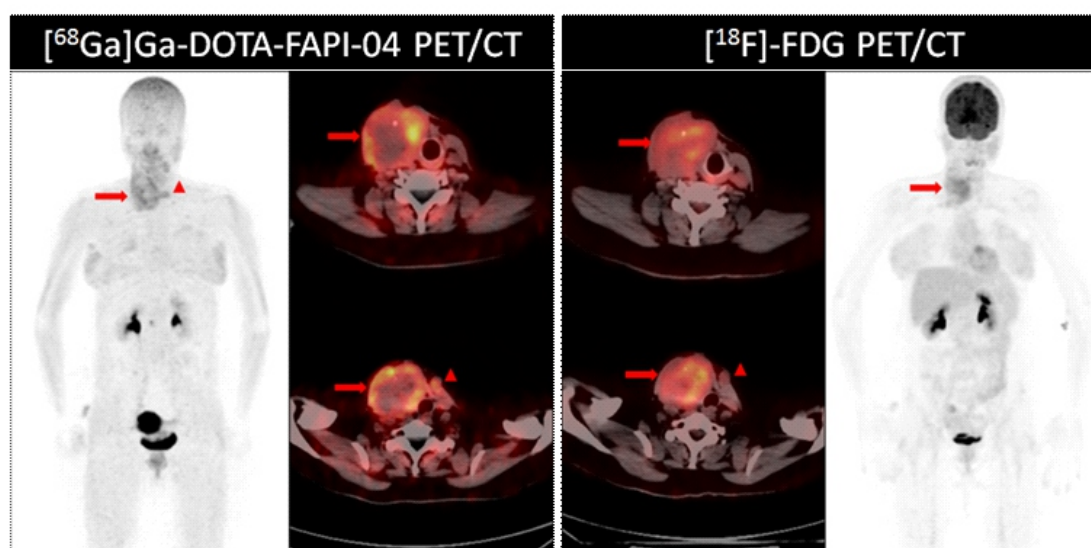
A-31-year-old woman with papillary thyroid cancer (Encapsulated follicular variant) who has had a total thyroidectomy and now has recurrent disease. Significant activity uptake was noted in conglomerated lymph nodes (arrow) on the right anterolateral side of the neck with both modalities (^{68}Ga -FAPI PET/CT SUVmax: 7.4; ^{18}F -FDG PET/CT SUVmax: 7.4). In contrast, ^{68}Ga -FAPI PET/CT imaging revealed a more distinct distribution of activity. In addition, the lymph node positioned on the left anterolateral side of the neck (arrowhead) demonstrated significantly enhanced ^{68}Ga -FAPI uptake (SUVmax: 3.7) but no substantial ^{18}F -FDG retention.
